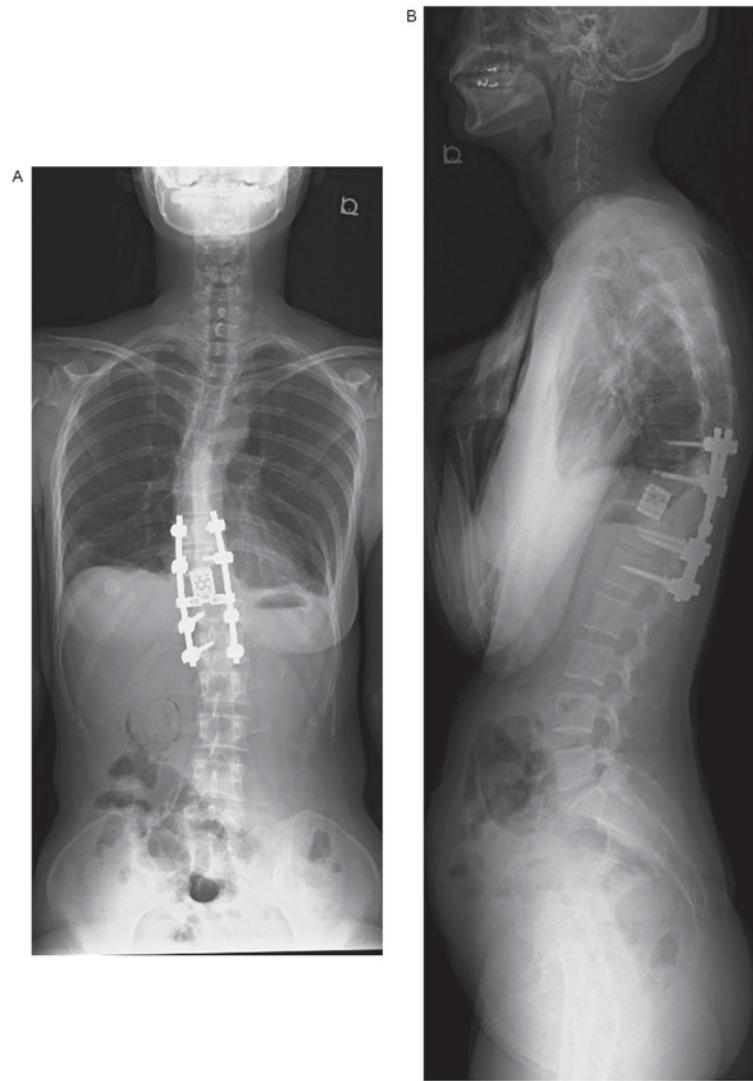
Plain radiographs of the whole spine 3 months after a total en bloc spondylectomy. (A) An anteroposterior view. (B) A lateral view.
